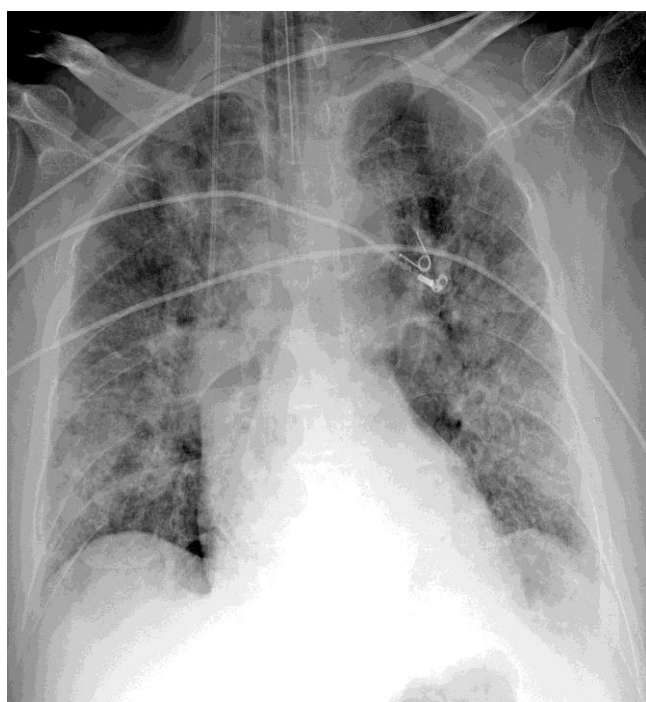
AP chest radiograph showing extensive bilateral ground-glass opacities (Stage 3) (28).
